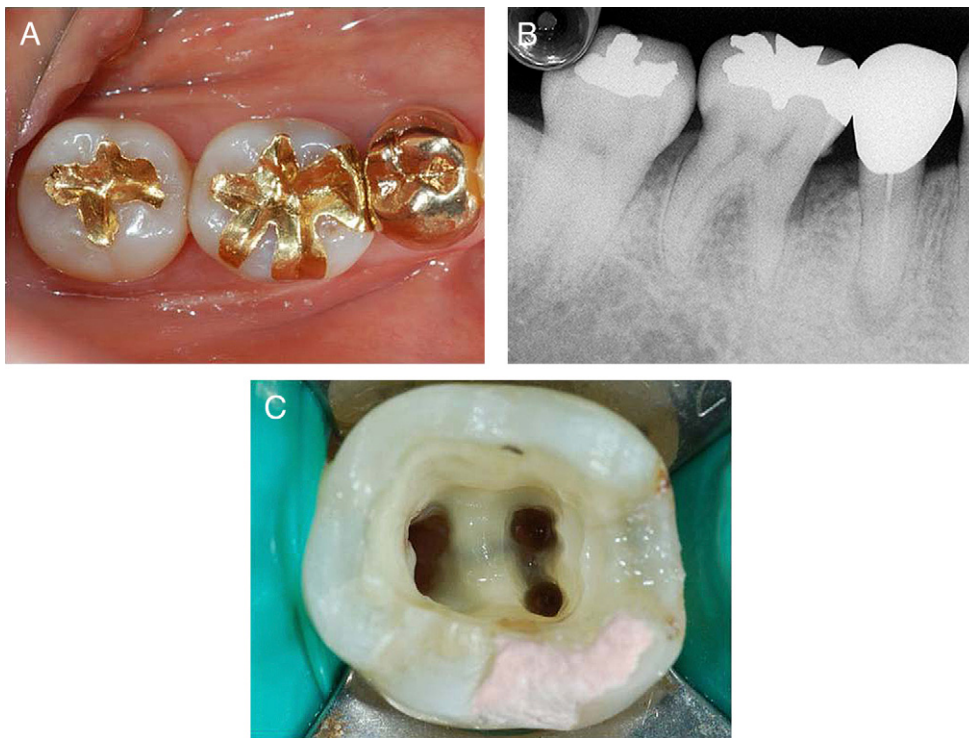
Pretreatment clinical (A) and radiographic view (B) of the right mandibular first molar with extensive gold restoration. (C) Floor of the pulp chamber showing conventional two orifices in the mesial root.
